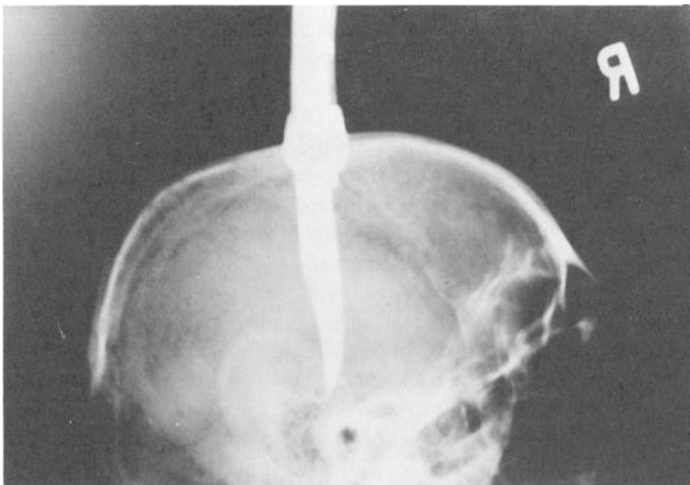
X-ray of the skull (lateral view).
